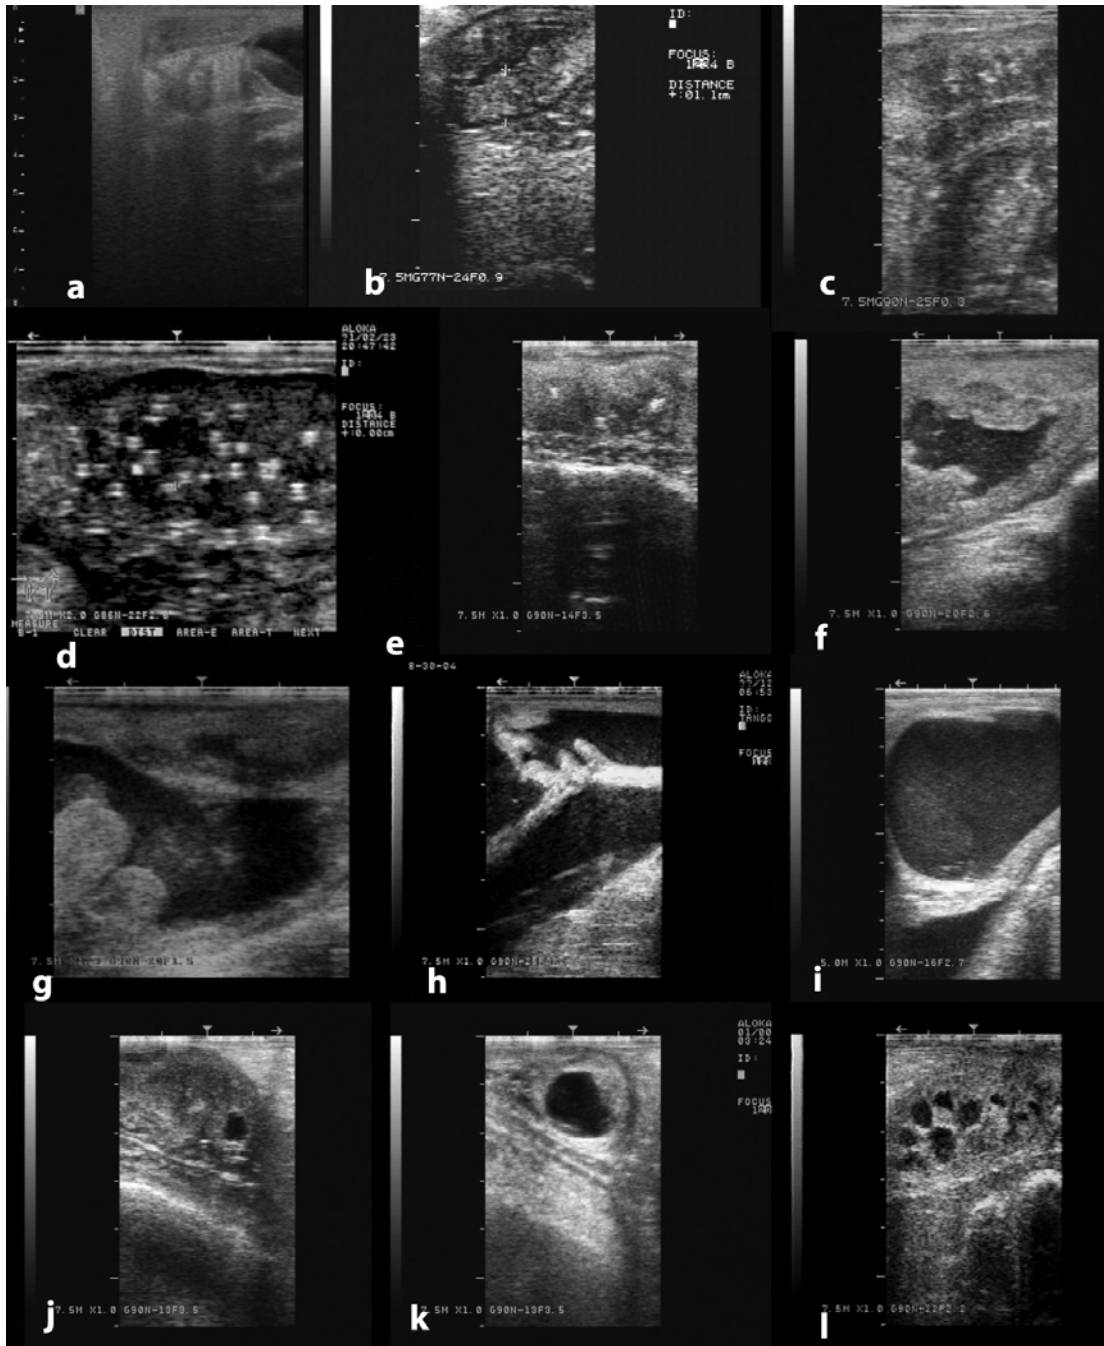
Ultrasonographic appearance of some disorders of the uterus. a) Infantile uterus, b) Endometritis, c) Chronic endometritis, d) Endometrial abscesses, e) Cervical adhesions, f) Pyometra; g) Post-fetotomy pyometra; g) mucometra due vaginal adhesions, note the open cervical rings, i) Mucometra due to vaginal aplasia, j-l) Uterine cysts.
